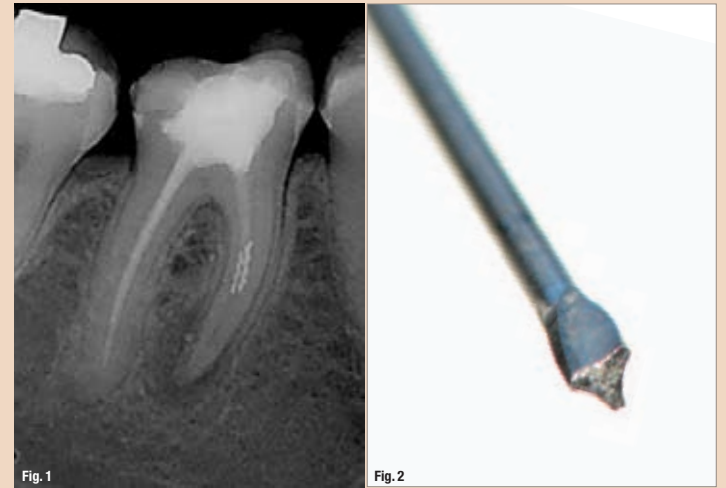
Diagnostic radiograph, showing two separated instruments in the mesial root.
